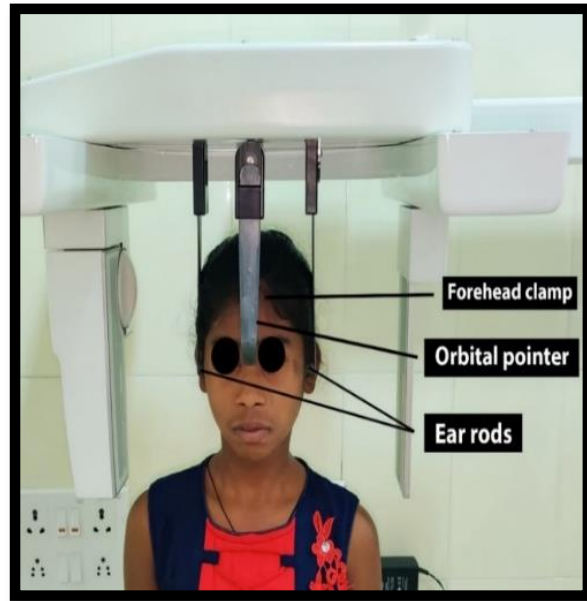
Technique of cephalometric radiography.
